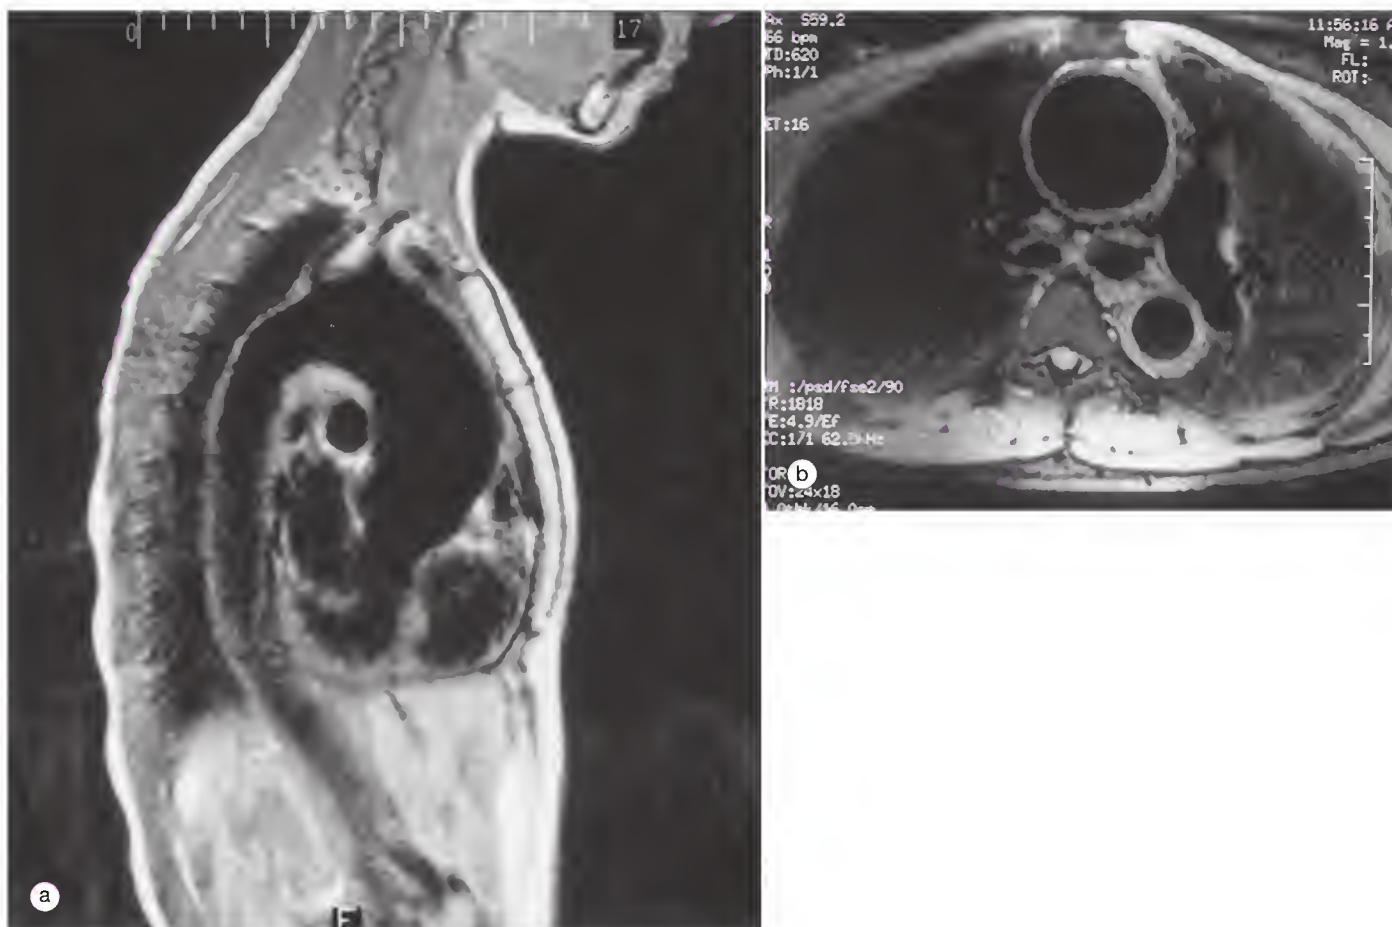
(a and b) Aneurysm of the aortic root seen on magnetic resonance imaging (T1-weighted images). The ascending aorta measures 5.0 cm and can be compared with the normal diameter of the descending aorta.
